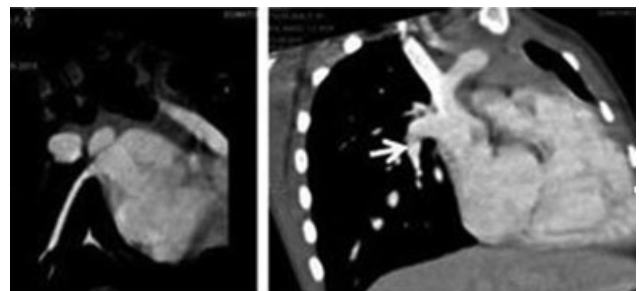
A 7-year-old female with ASD. MDCT shows a small tributary of RIPV opening into SVC—cardiac type (marked by arrows). MDCT, multidetector computed tomography.
